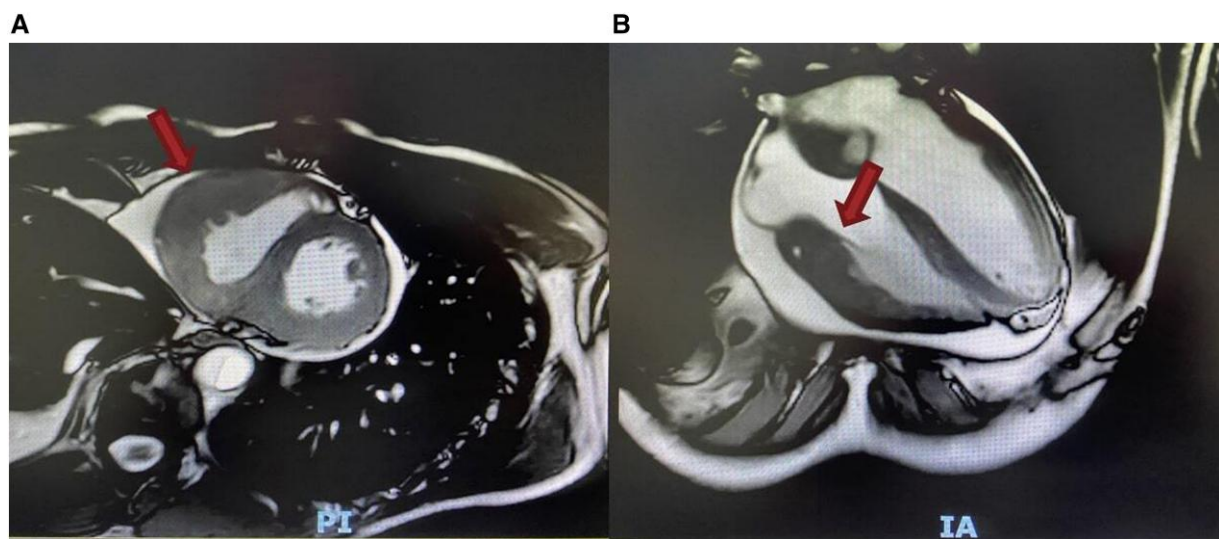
Cardiac magnetic resonance imaging confirmed thickening of the right ventricular free wall due to myocardial infiltration (arrows) in short-axis view (A) and four-chamber view (B).
